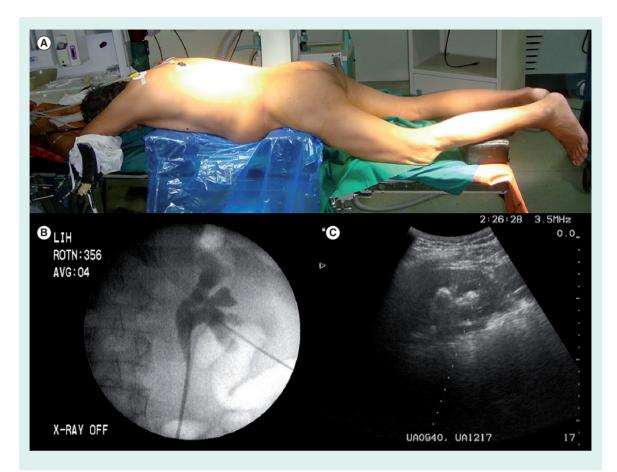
Position for percutaneous nephrolithotomy and fluoroscopy. Ultrasound and fluoroscopy-guided puncture. (A) Bolsters below the hip and chest to allow the abdominal contents to drop forward along with adequate padding in prone position. (B) The ideal tract in percutaneous nephrolithotomy traverses a posteriorly facing papilla tip of an end-on calyx seen here in fluoroscopy. (C) Ultrasound guided puncture of the lower posterior calyx to achieve access into the stone-bearing calyx. Note the puncture guide (dotted line), which acts a visual marker to help in gaining the access.
